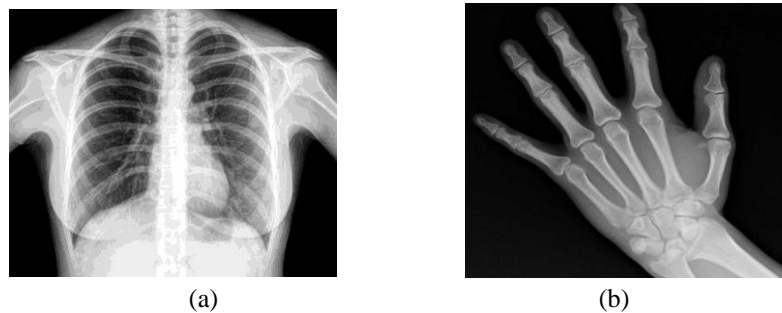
1: Example of X-ray images (a) Chest (b) Hand
